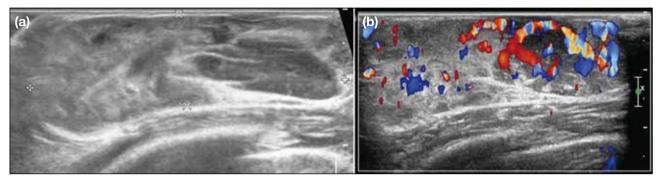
A 4-month-old female infant was noted to have a rapidly enlarging right breast mass since 2 weeks of age. Targeted ultrasound [US] (a) shows a mixed hypoechoic and hyperechoic mass in the right breast with multiple dilated vessels on colour Doppler US (b), compatible with the clinical diagnosis of infantile haemangioma.
